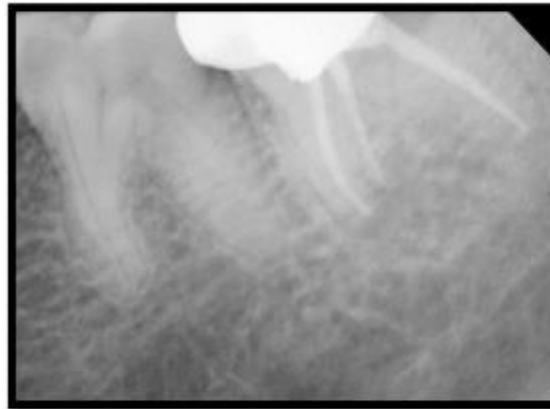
Radiograph showing follow up of #37 after 6 months
